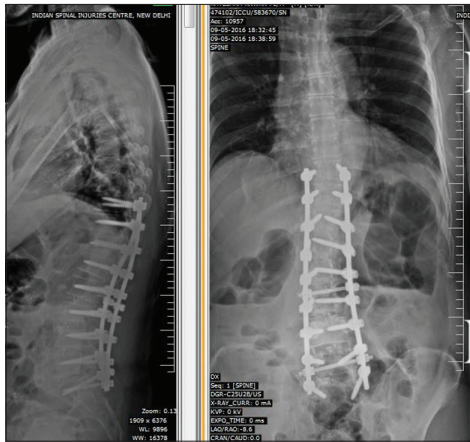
Postoperative lateral and anteroposterior whole spine X-rays of patient 2 on follow-up showing pedicle screw instrumentation from T10-S1 with correction of scoliosis.
